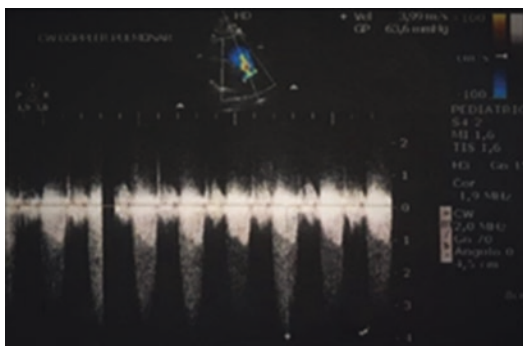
Transthoracic echocardiography with Doppler showing stenosis of the pulmonary valve
